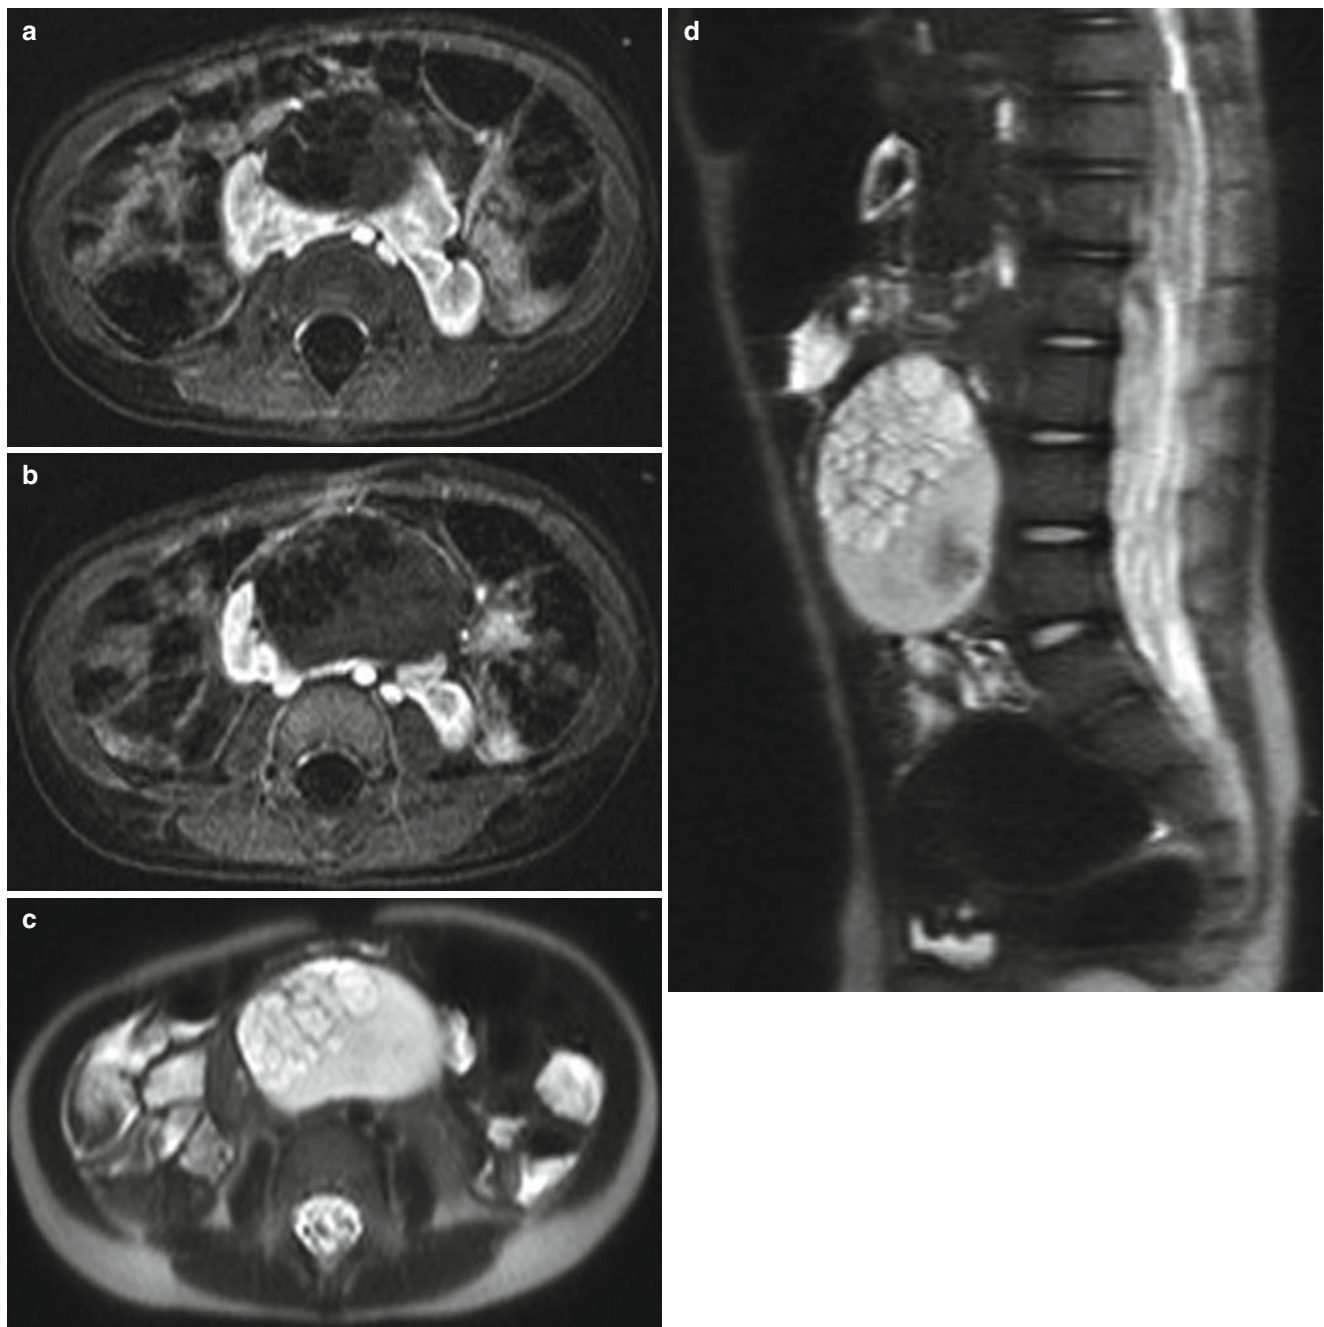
Cystic Wilms tumor in a horseshoe kidney in a 2-year-old girl. (a and b) Contrast-enhanced T1-weighted axial MR images demonstrate a multiseptated, cystic, and partially solid mass arising from
